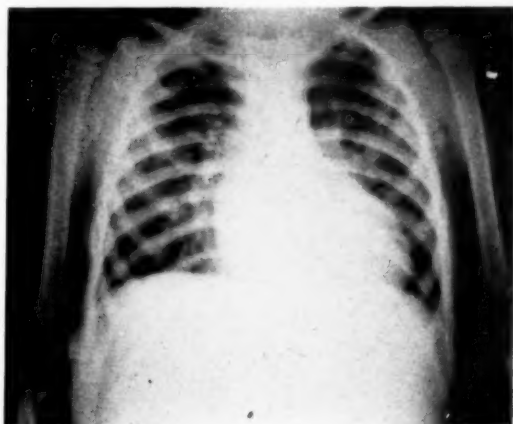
Roentgenogram of the chest showing the typical cardiac silhouette. Note the absence of the shadow normally cast by the pulmonary conus.
